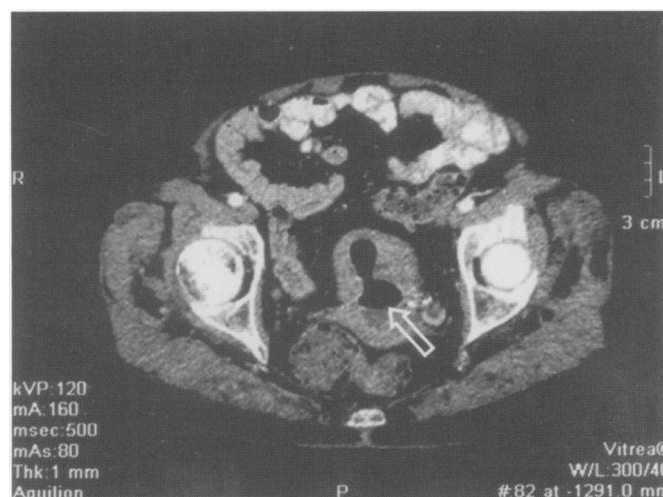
Transverse multidetector computed tomography section showing fundus of uterus with abscess cavity containing air, fluid and debris (white arrow).
